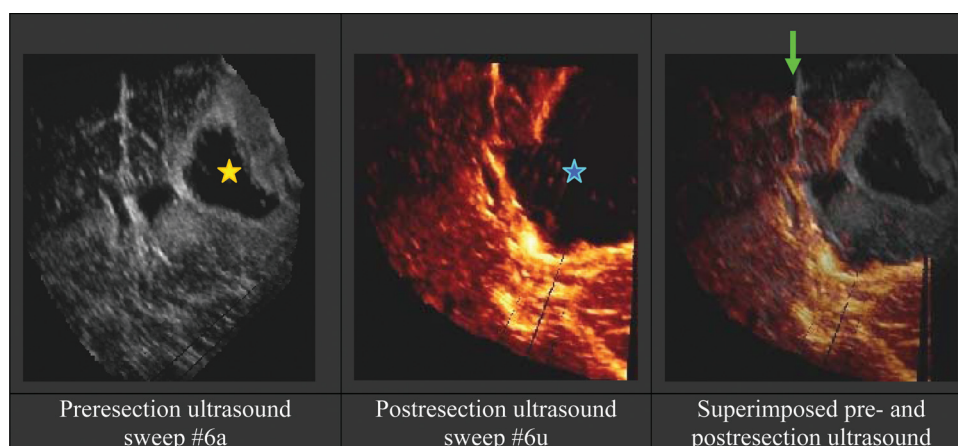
Reslices of two ultrasound volumes acquired for patient #6. Left: preresection ultrasound of a tumor with a large cyst (yellow star). Center: postresection ultrasound. The resection cavity (blue star) is very large and includes the lateral ventricle. Right: superimposed pre- and postresection ultrasound. A small visible shift can be seen between the two (green arrow).
